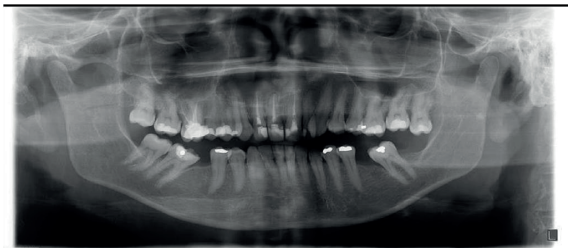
Initial clinical and radiographic appearance.
